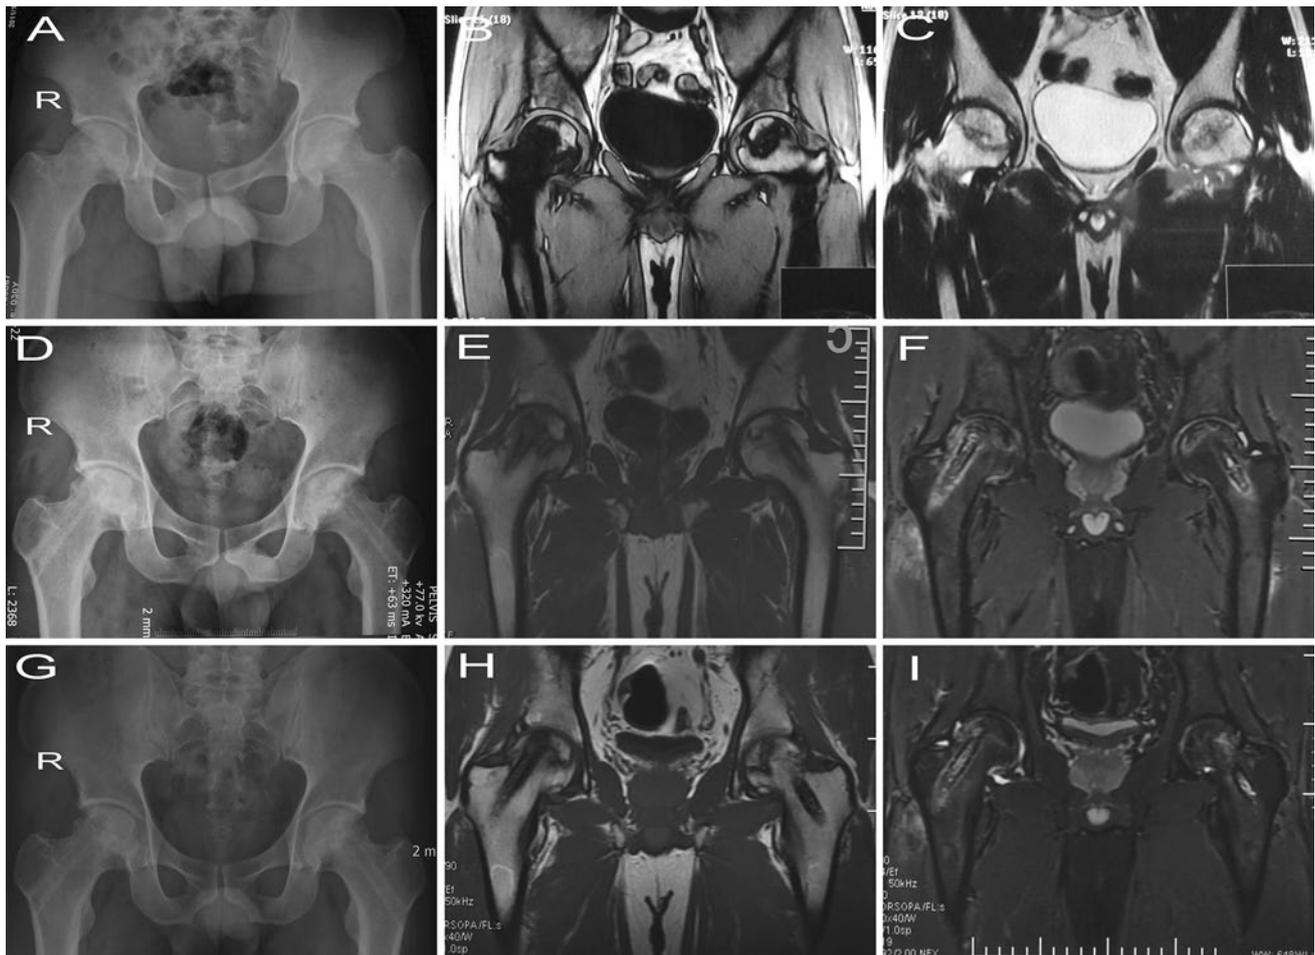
Representative radiographs from a bilateral case with Steinberg stage IIC that was successfully treated with CD in combination with a n-HA/PA66 rod and bioglass bone graft. X-ray and MRI (T1
